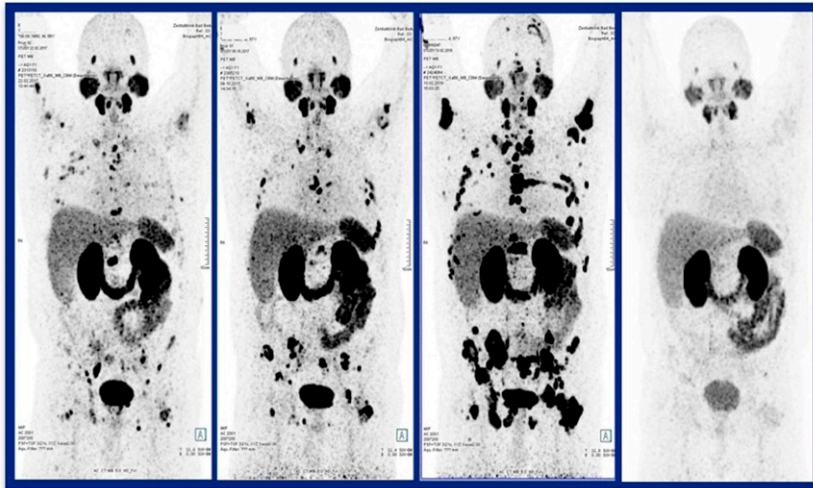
^{225}Ac - and ^{177}Lu -labeled prostate-specific membrane antigen (PSMA) ligands for treatment of progressive end-stage metastatic prostate cancer. The researchers combined the 2 agents (referred to as tandem $\alpha\beta$ -PSMA-targeted radioligand therapy [PRLT]) in 24 patients. ^{68}Ga -PSMA images are shown in a patient who experienced disease progression through 3 cycles of ^{177}Lu -PRLT (left 3 images: pre-PRLT1, PSA = 0.93; post-PRLT2, PSA = 11.2; post-PRLT3, PSA = 137). After tandem $\alpha\beta$ -PRLT (right image), marked response was observed, and the PSA was 0.9.
